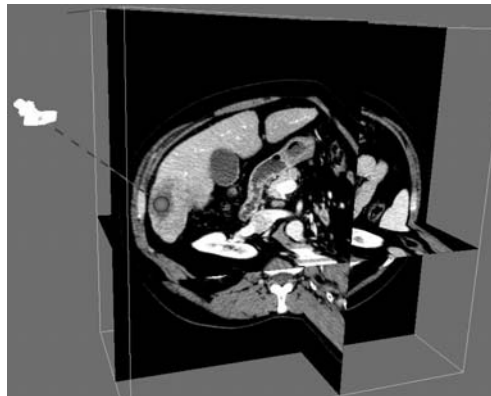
Patient CT image displayed in the virtual exterior view. One can see a green sphere target that was put by the user.
